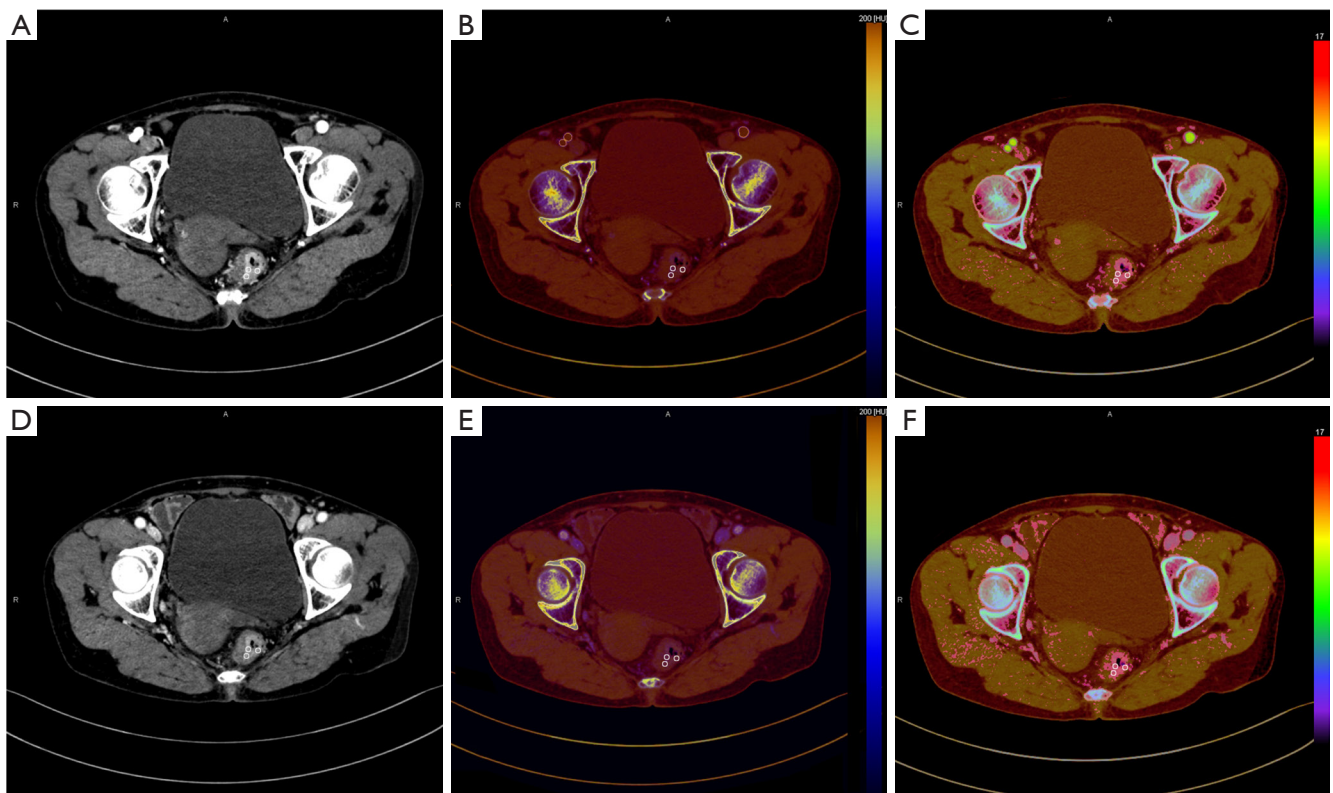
A 70-year-old man with rectal cancer, pathologically confirmed as a moderately differentiated adenocarcinoma but with six lymph node metastases. (A) Images with optimal SNR and CNR at 40 keV VMI+ in the arterial phase; (B) DECT images of IC in the arterial phase; (C) images of the effective atomic number and electron density in the arterial phase; (D) images of 40 keV VMI+ in the venous phase; (E) DECT images of IC in the venous phase; (F) images of the effective atomic number and electron density in the venous phase. SNR, signal-to-noise; CNR, contrast-to-noise ratio; VMI+, virtual monoenergetic imaging based on Mono+ algorithm; DECT, dual-energy computed tomography; IC, iodine concentration.
